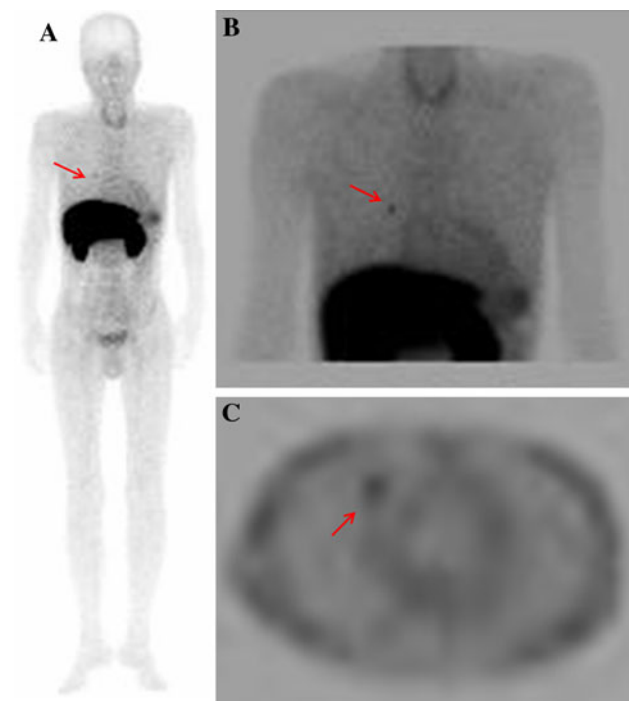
Scintigraphy using ^{99m}Tc aprotinin shows nodular uptake in the middle lobe of the right lung. Significant uptake is also observed in the myocardium (left ventricular myocardium), suggesting cardiac amyloidosis. Anterior and posterior planar images (a, b) and single photon emission computed tomography (SPECT) image (c)
